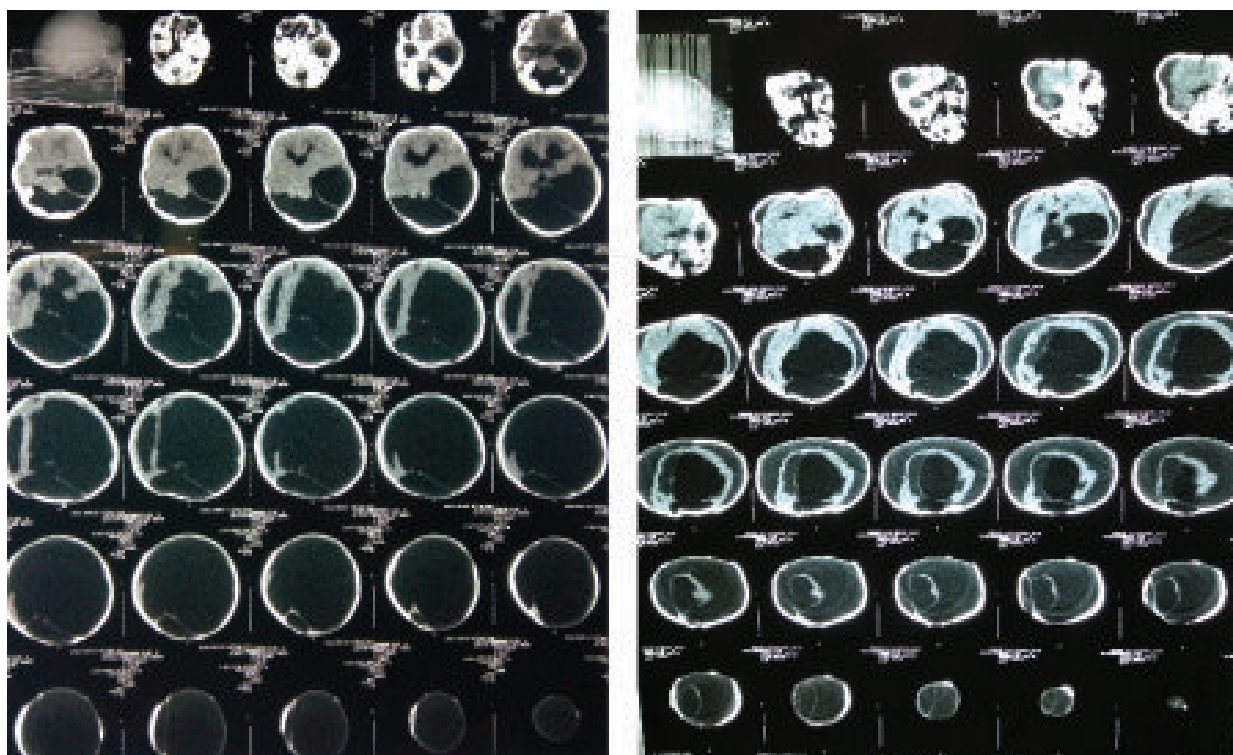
(a) CT scan of head at 12 days of age showing markedly dilated ventricles and thinning of cortical mantle. (b) CT scan of head at 4 months of age showing decrease of ventricular size after CSF leakage with subdural hygroma.
